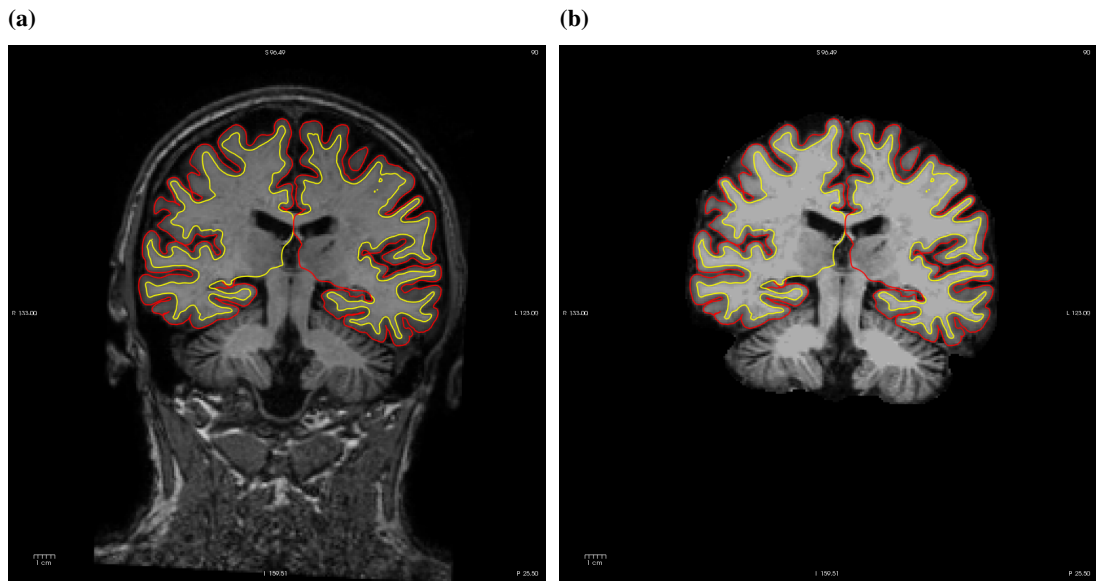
The 90th slice of a brain MR image in the coronal view processed by FREESURFER, which is displayed with (a) ‘nu.mgz’ and (b) ‘brainmask.mgz’ brain profiles.
